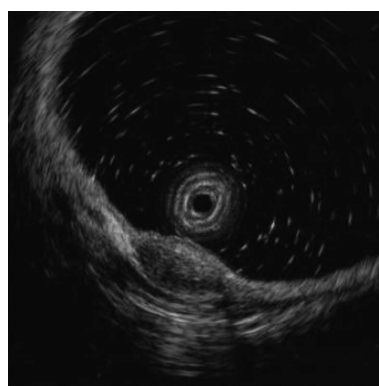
Endoscopic ultrasonographic features of the rectal submucosal tumor. An approximately 1.0 cm × 0.5 cm, hypoechoic lesion in the deep mucosa and submucosal layer.
